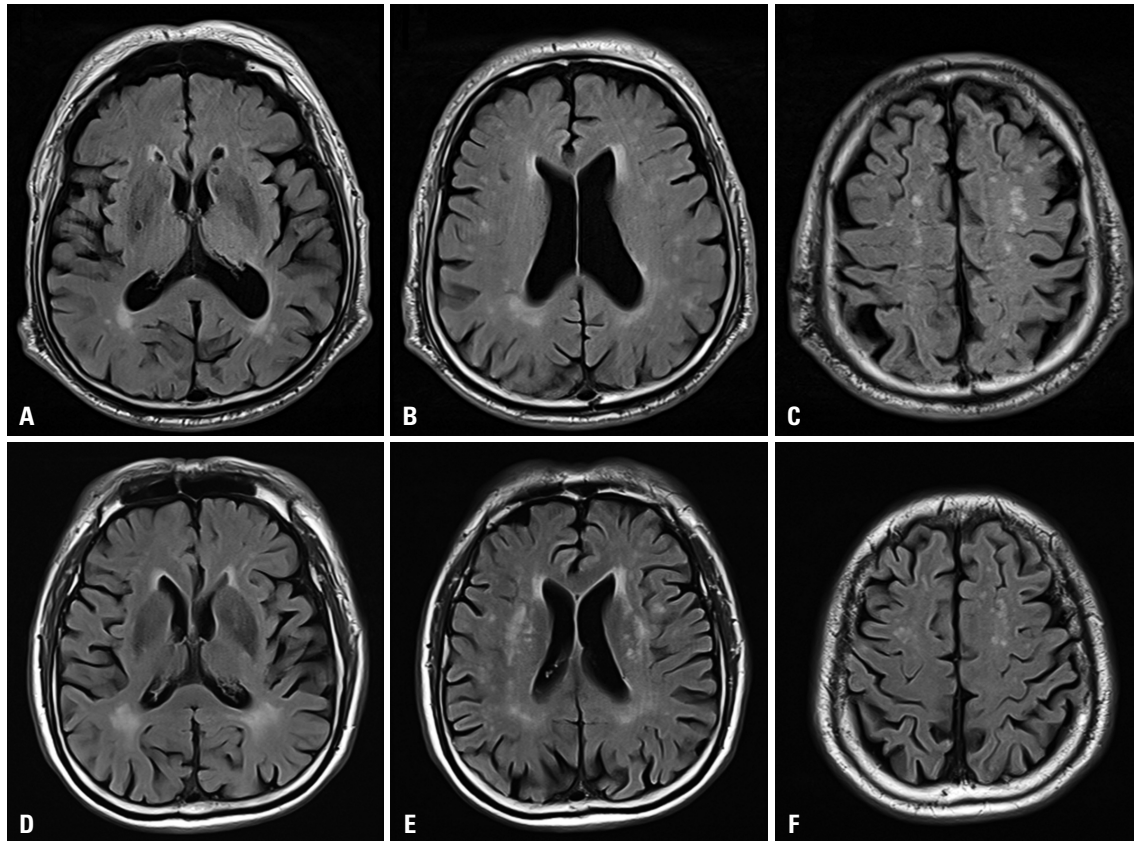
Axial fluid-attenuated inversion recovery MR images of III-6 patient from MF1531 and age- and sex-matched healthy controls. There were no significant differences in white matter changes between patients with AGel amyloidosis (A-C) and healthy controls (D-F).
